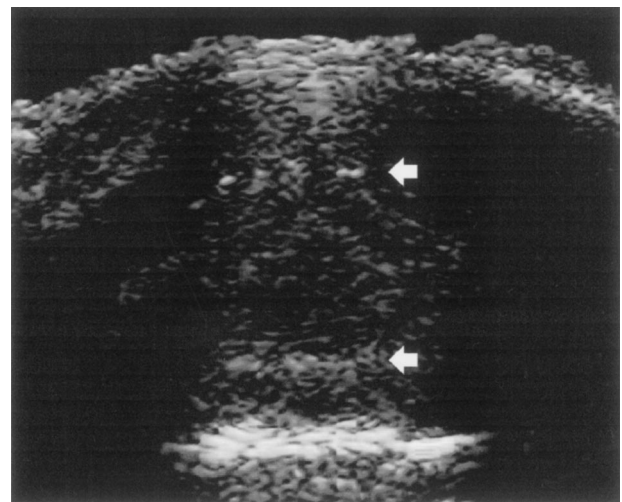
Ultrasonic image of an intervertebral disc taken in the transverse plane. Arrows indicate the bright echoes originating at the border of the nucleus pulposus.
